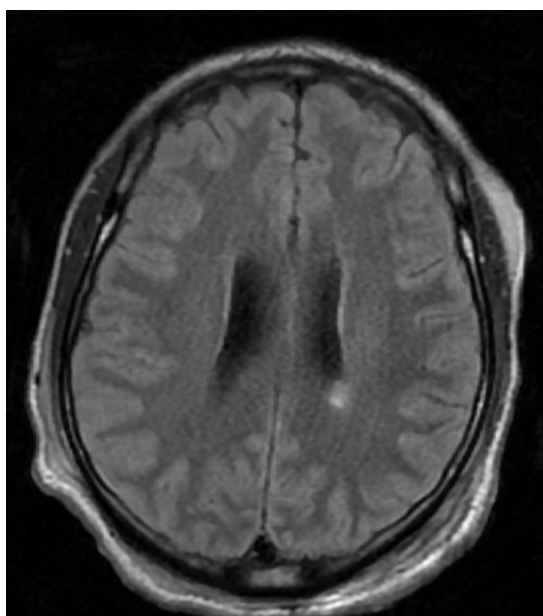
Axial T2 FLAIR: Nodular demyelinating lesions with T2 FLAIR hyperintensity in the juxtaventricular white matter of the bilateral parieto-occipital region
